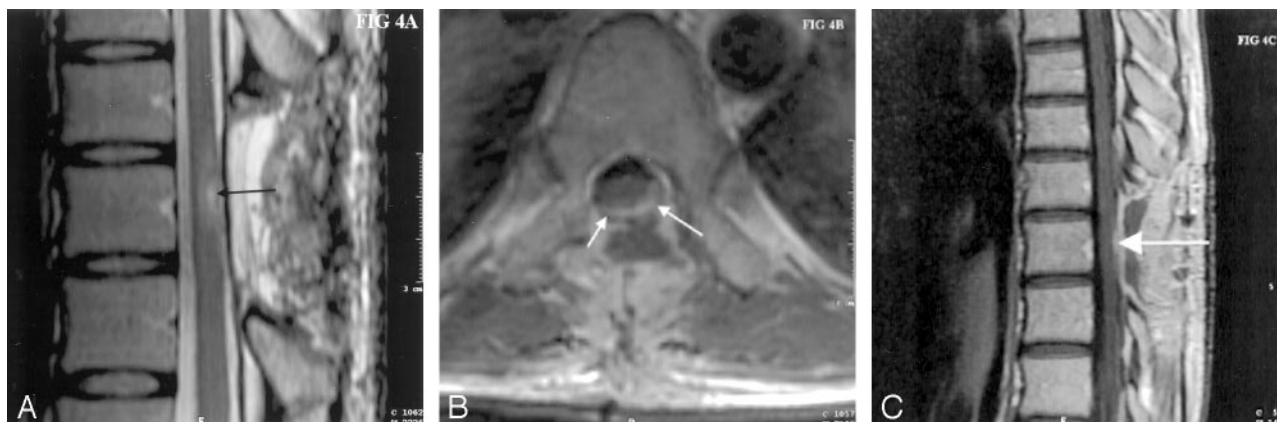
Postoperative MR images.
